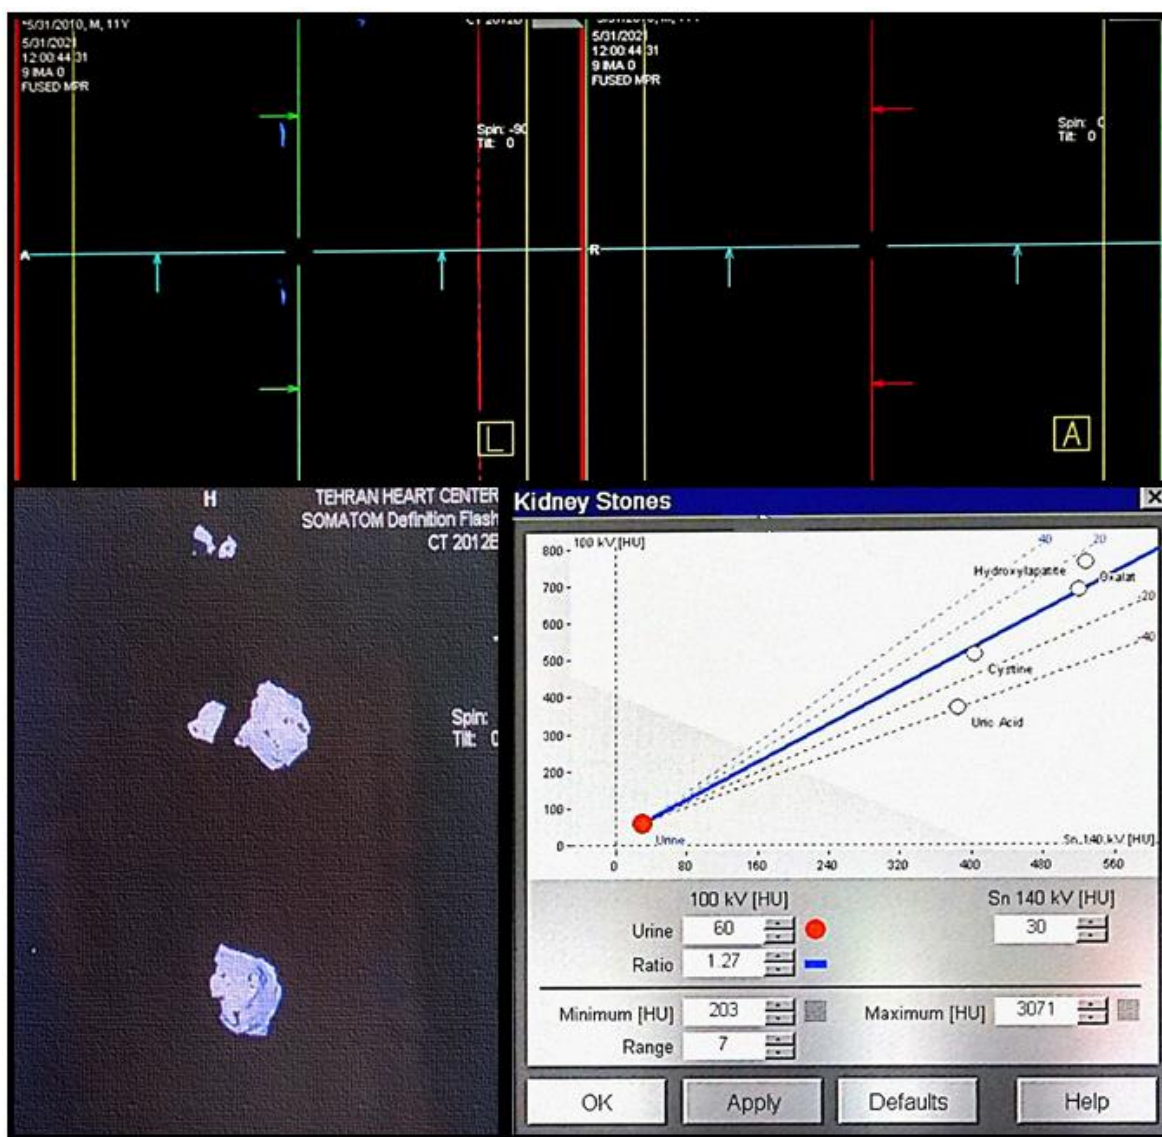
Dual-energy study curve, for evaluation of the chemical composition of cyst wall, shows blue encoding compatible with highly calcified structure. The curve was depicted on Leonardo work station, medical Siemens Somatom definition CT
